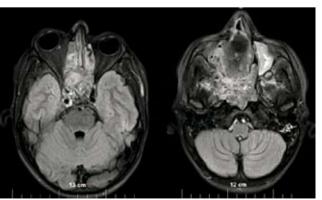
Diagnostic MRI before treatment
